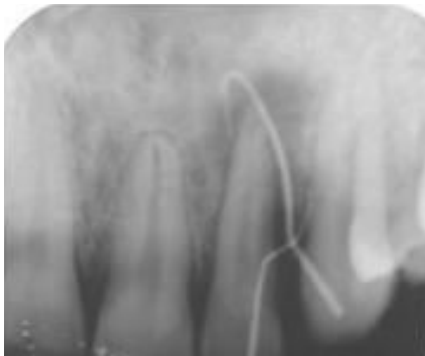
I(c). IOPA radiograph showing two gutta percha cones-one tracing through the sinus and other through the groove.
